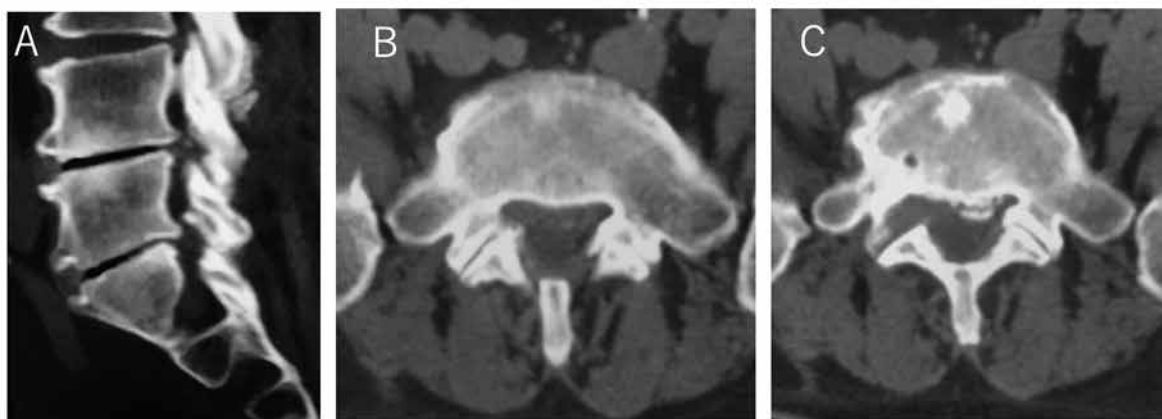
Computed tomography scans acquired after surgery. Epidural gas is not evident on sagittal (A) or axial (B) scans. (C) shows the area where the foraminoplasty was performed to create space for insertion of a cannula into the neural canal.
